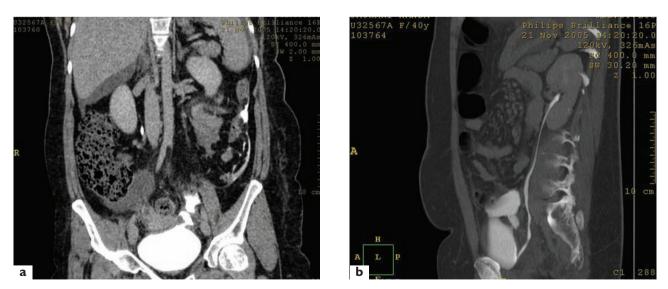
Complication: case of vesicoperitoneal fistula. Computed tomography scan (a) and (b). Leakage of contrast medium from the bladder to the peritoneal cavity. The diagnosis was made on day 6 post-op. A Foley catheter was left in place for 14 days
